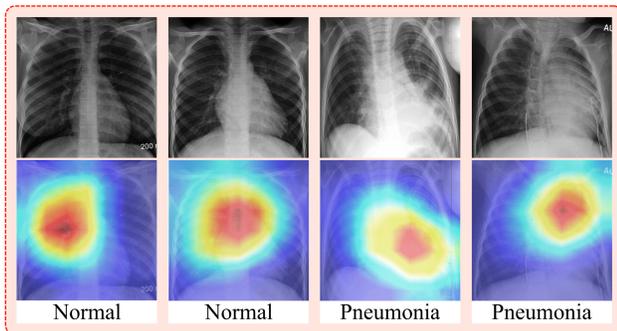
Class activation maps output of four randomly chosen chest X-ray images from the test subset.
